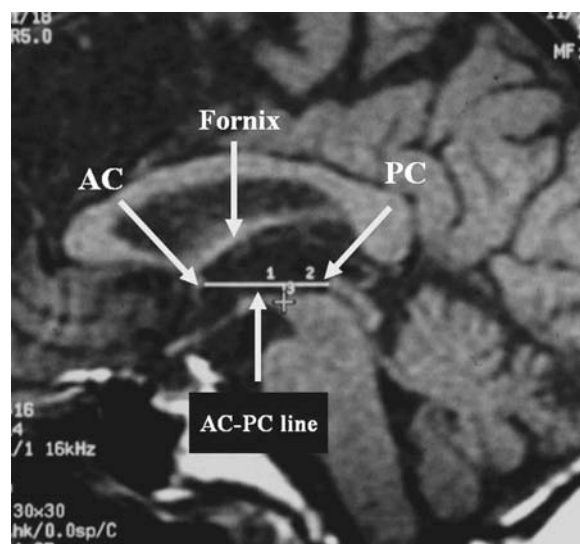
Sagittal T1 weighted magnetic resonance imaging (MRI) scan showing the AC, which is defined at the anterior wall of the third ventricle. The PC is placed at the posterior wall of the third ventricle, directly above the beginning of the Aqueduct. The AC–PC line is of the utmost importance in functional neurosurgery. The coordinates established in the major stereotactic atlases were defined using this line as reference.
